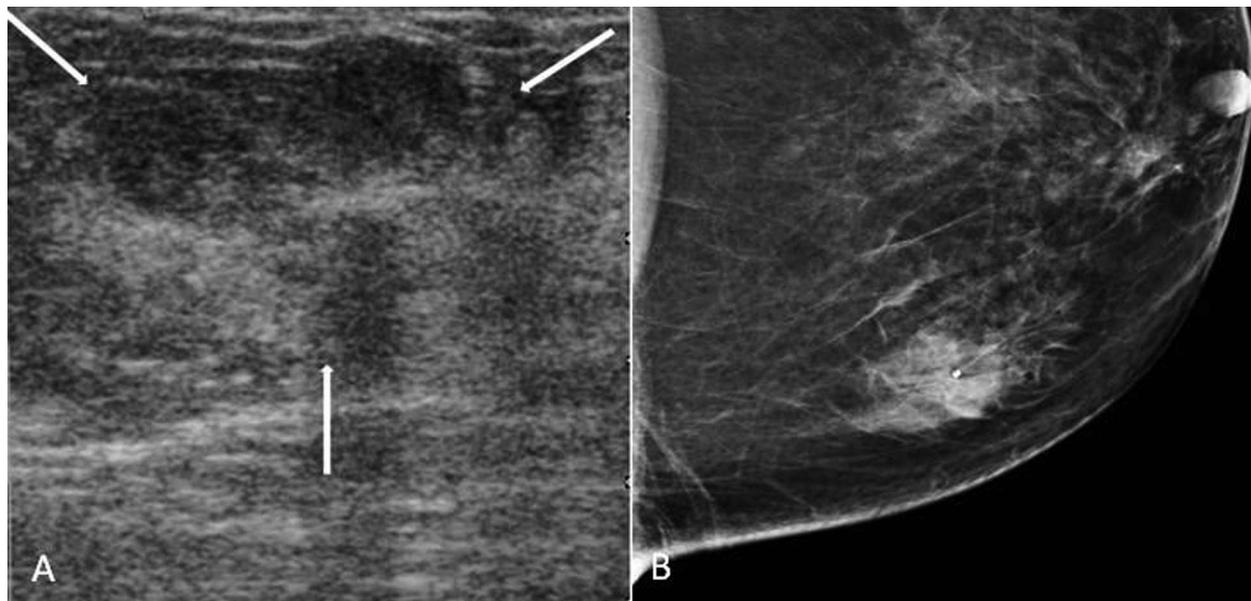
A, Transverse sonogram obtained for assessment of a suspicious mass (arrows) seen on mammography (B), appearing as an irregular heterogeneous noncircumscribed hyperechoic mass. The central shadowing seen on the sonogram is related to the postbiopsy clip marker deployed within the mass. Biopsy showed invasive mucinous cancer.
